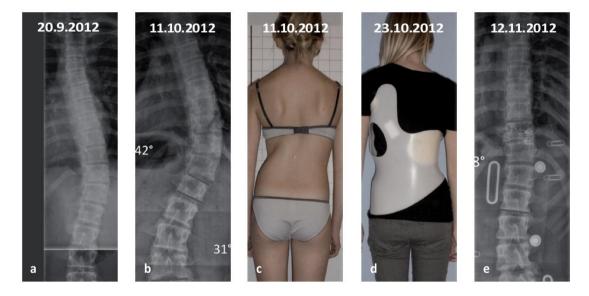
Patient with scoliosis and vast progression in the short-term prior to brace treatment with the x-rays made according to the least possible exposure to radiation. The region of interest (ROI) is clearly visible and in this girl even with a reduction of the exposure time the structural entities of the bony tissue are visible.
